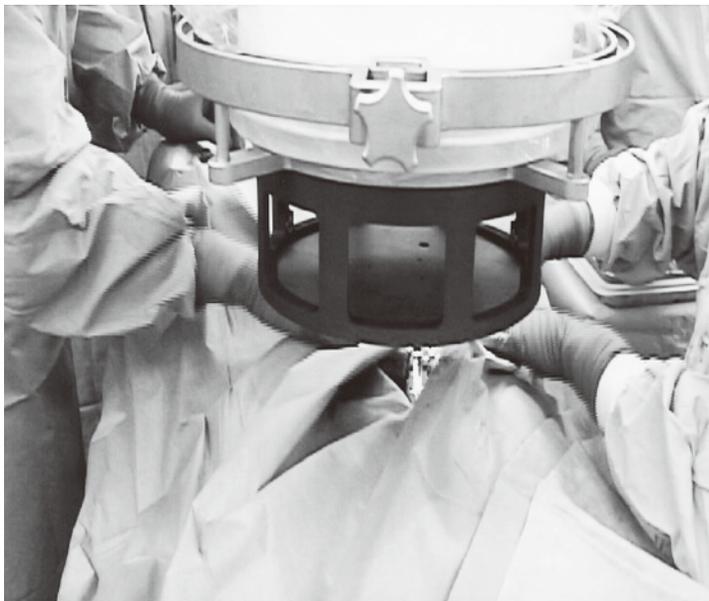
X-ray registration kit with reflective marker discs was mounted on image intensifier in a sterile environment. Both AP and lateral fluoroscopies included three vertebrae, L4, L5, and S1.
